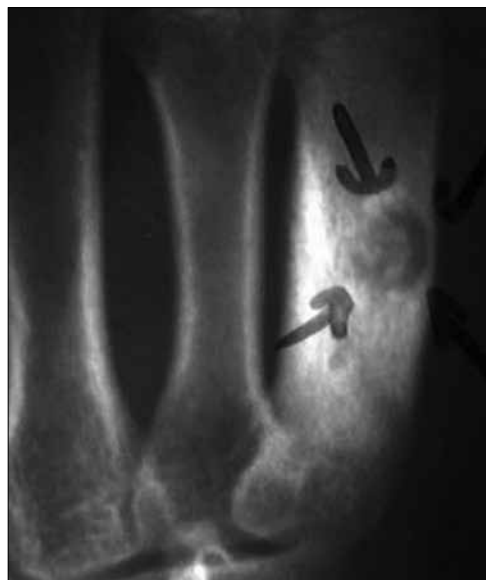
Plain radiograph of the first patient shows nidus and surrounding sclerotic bone
